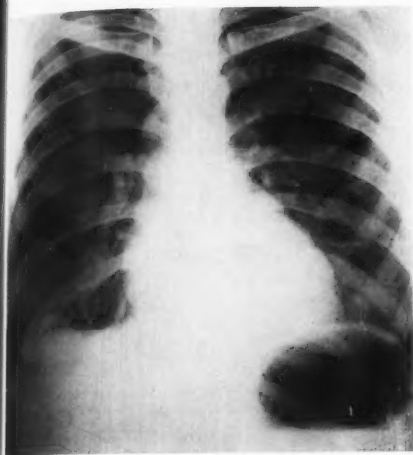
(Case No. 1.) Plain P.A. radiograph of chest.
